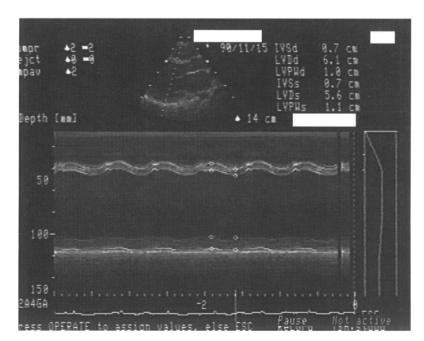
M mode echocardiogram showing increase of left ventricular end diastolic (61 mm) and end systolic (56 mm) cavity dimension and reduced percentage of fractional shortening (8%).
